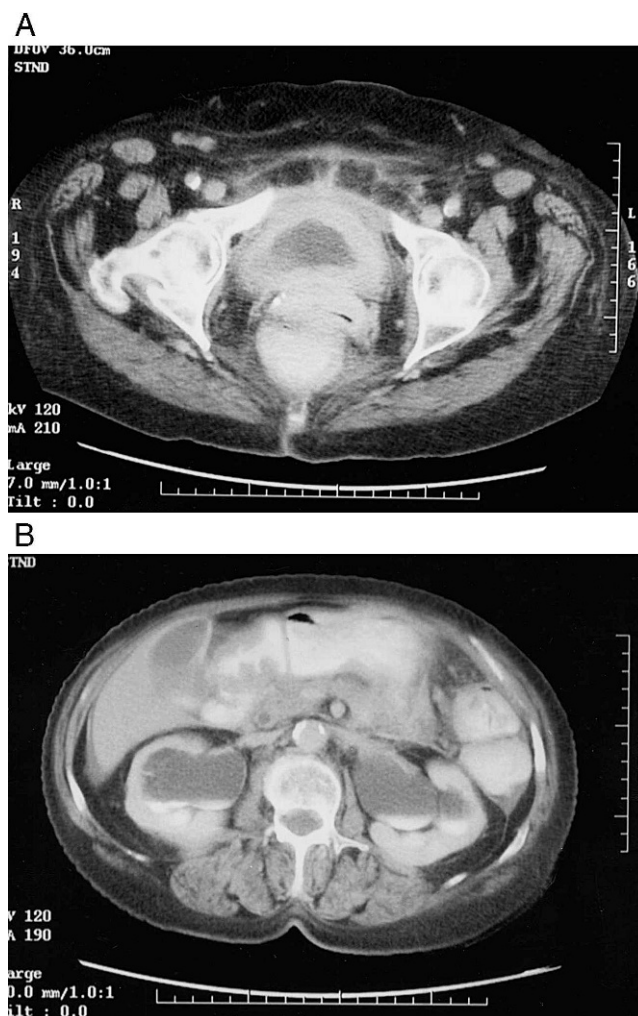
A. CT scan revealing extensive bladder wall thickening and filling defect. Figure B. Bilateral hydronephrosis as a result of ureteral compression.
